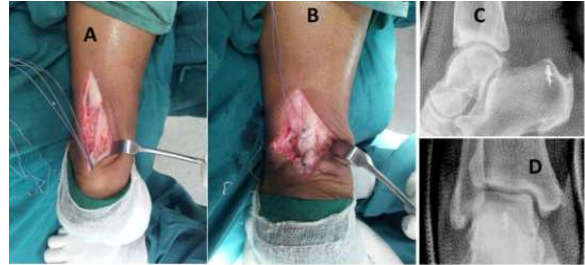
The insertional rupture of the tendoachillis (A) and the repair of the tendoachillis using an anchor (B). The lateral (C), anteroposterior (D) radiograph showing the anchor in situ.
